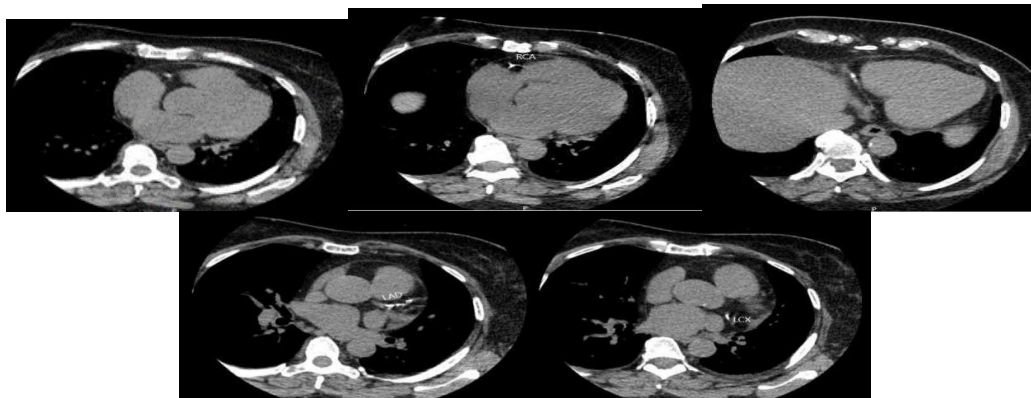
CT Calcium scoring- LAD, LCX and RCA.
